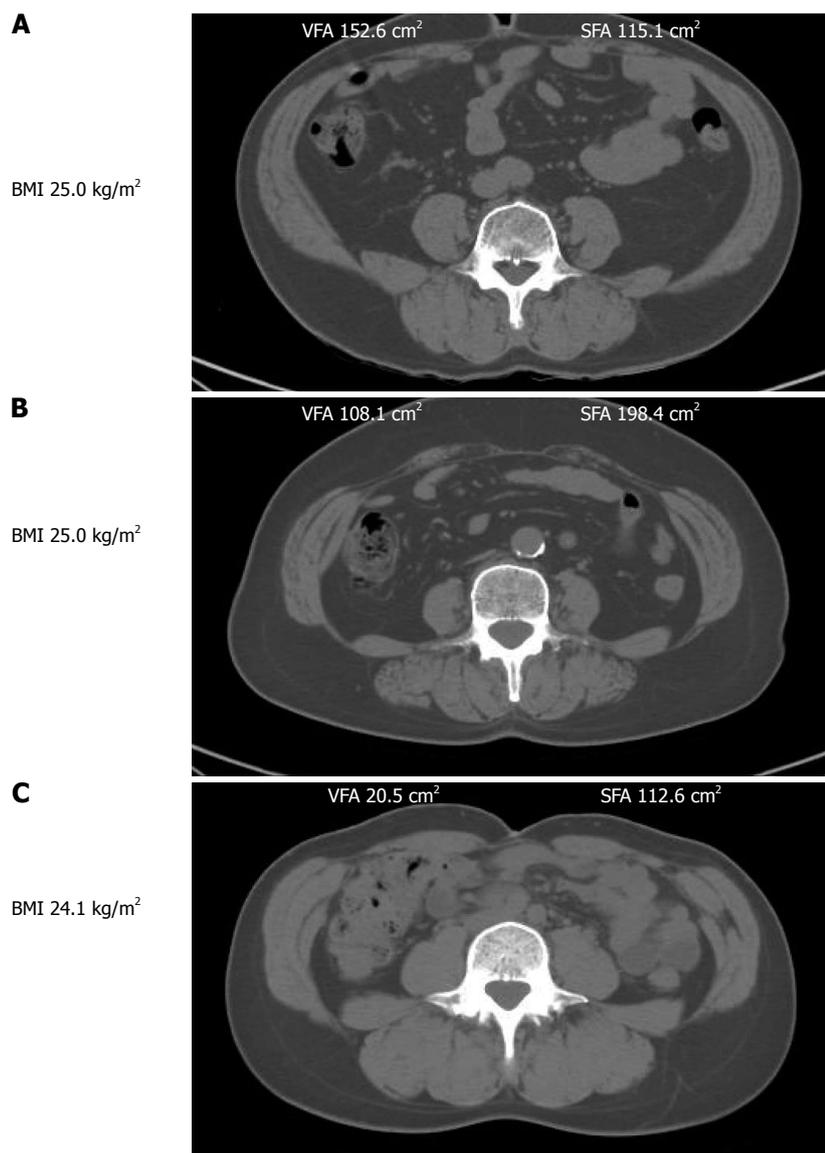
Differences in fat distribution based on sex and age. CT scans of the abdomen in three representative subjects. A: A 60-year-old male; B: A 60-year-old female; C: A 40-year-old female. Fat area measurement application: Advanced area calculation, GE Healthcare Co. CT: Computed tomography; BMI: Body mass index.
